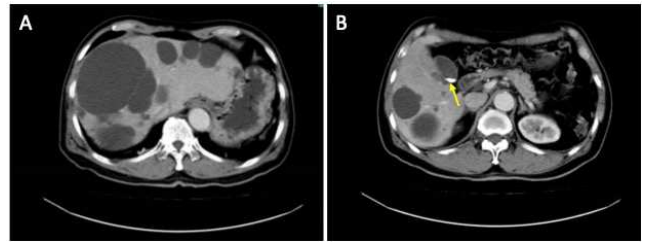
Computed tomography (CT) scan images. (A) The CT scan shows multiple cystic low-density lesions with clear boundaries, in which the biggest cyst lies in segment 5/8 with a size of 106mm×82mm. (B) Sediment-like stones can be seen in the gallbladder (arrow).
